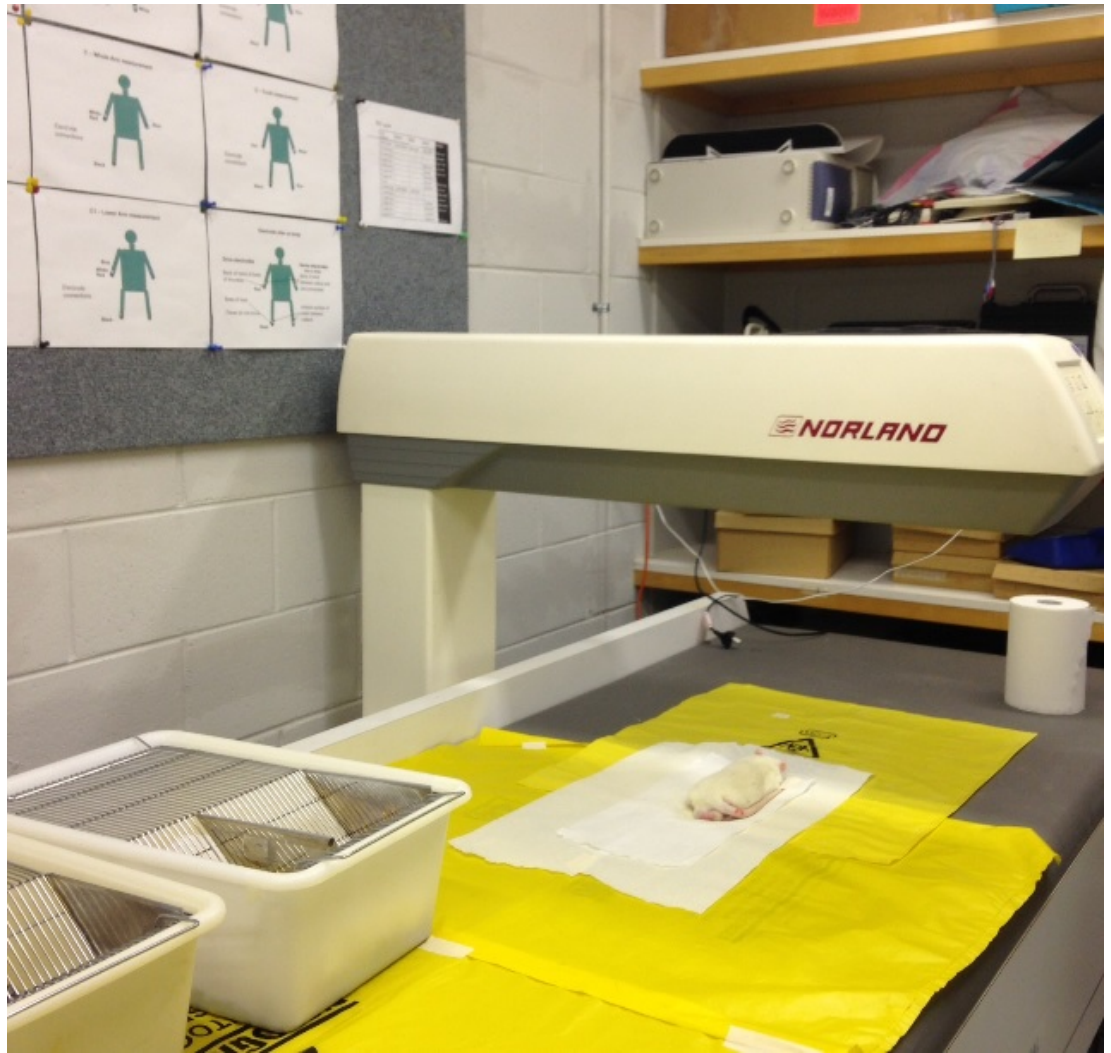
Dual energy X-ray absorptiometry (DXA) machine for scanning for body composition
